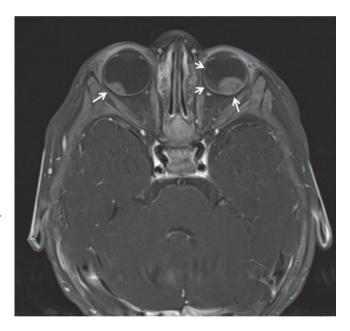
Axial T1 MRI image showing bilateral intraocular masses in an 8-month-old infant with retinoblastoma (*arrows*)
